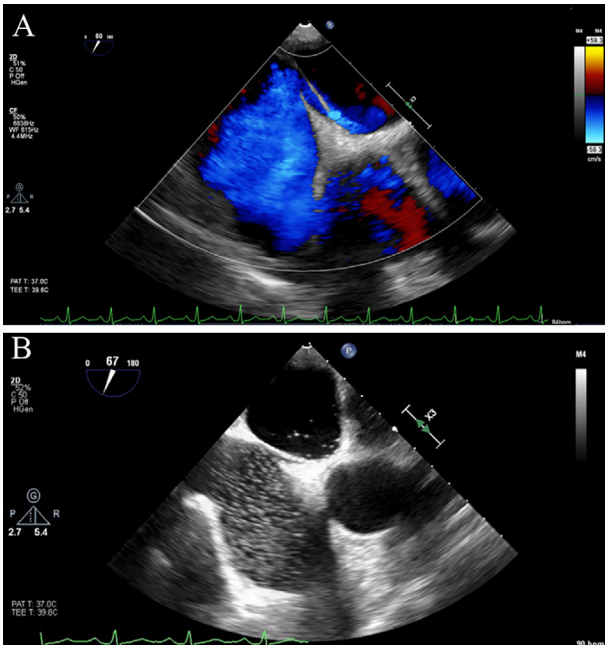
(A) After 8 days of anticoagulant therapy, transesophageal echocardiography revealed right and left shunts in the patent foramen ovale. (B) The bubble test was positive, showing moderate bubbles in the left heart system.
